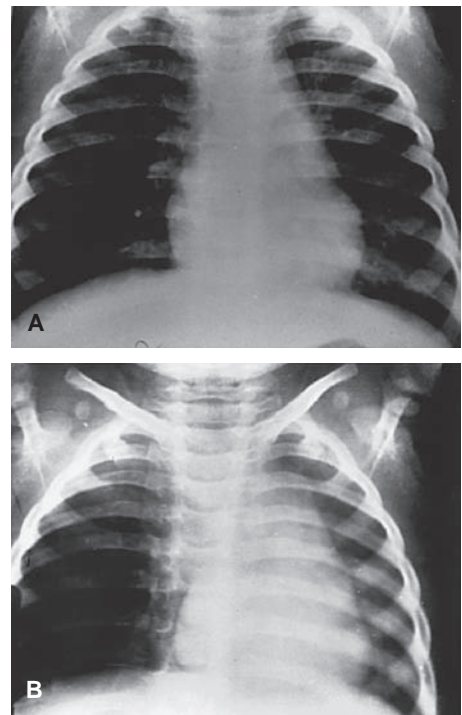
Chest radiograph of child with bronchial foreign body. A: Inspiratory film demonstrates only subtle hyperaeration of right lung. B: Expiratory film shows accentuated hyperaeration on the right side secondary to air trapping (“ball-valve” phenomenon) by the foreign body in the right mainstem bronchus. In addition, the mediastinum is displaced to the left.
